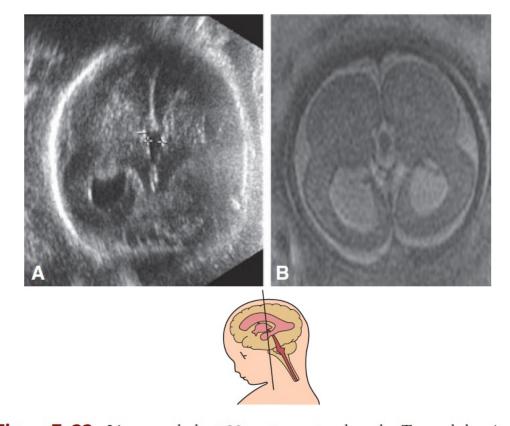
Lissencephaly at 33 postmenstrual weeks. Transabdominal US (A) and MRI (B) axial planes show the lack of sulcation colpocephaly with thick cortex and mild ventriculomegaly. Note the "figure eight" configuration in the MRI.
